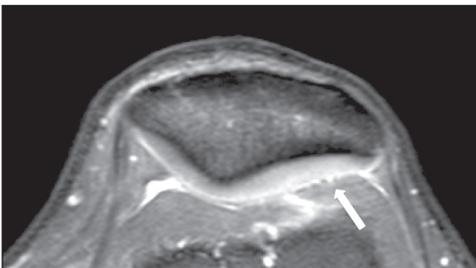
33-year-old, male. T1-weighted MR image shows surface irregularity in medial facet (arrow), softening and swelling of the cartilage in patellar facet consistent with grade 1.
